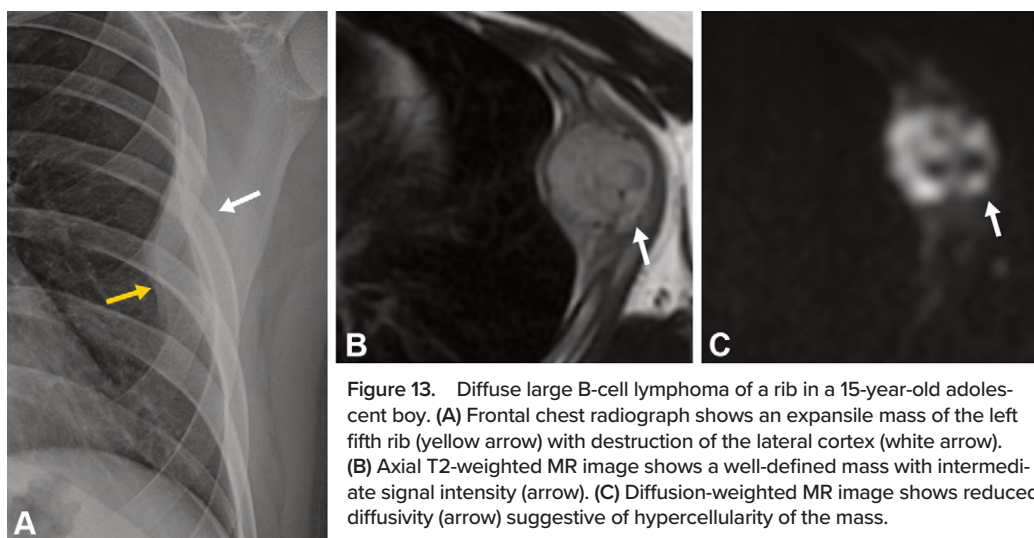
Diffuse large B-cell lymphoma of a rib in a 15-year-old adolescent boy. (A) Frontal chest radiograph shows an expansile mass of the left fifth rib (yellow arrow) with destruction of the lateral cortex (white arrow). (B) Axial T2-weighted MR image shows a well-defined mass with intermediate signal intensity (arrow). (C) Diffusion-weighted MR image shows reduced diffusivity (arrow) suggestive of hypercellularity of the mass.
